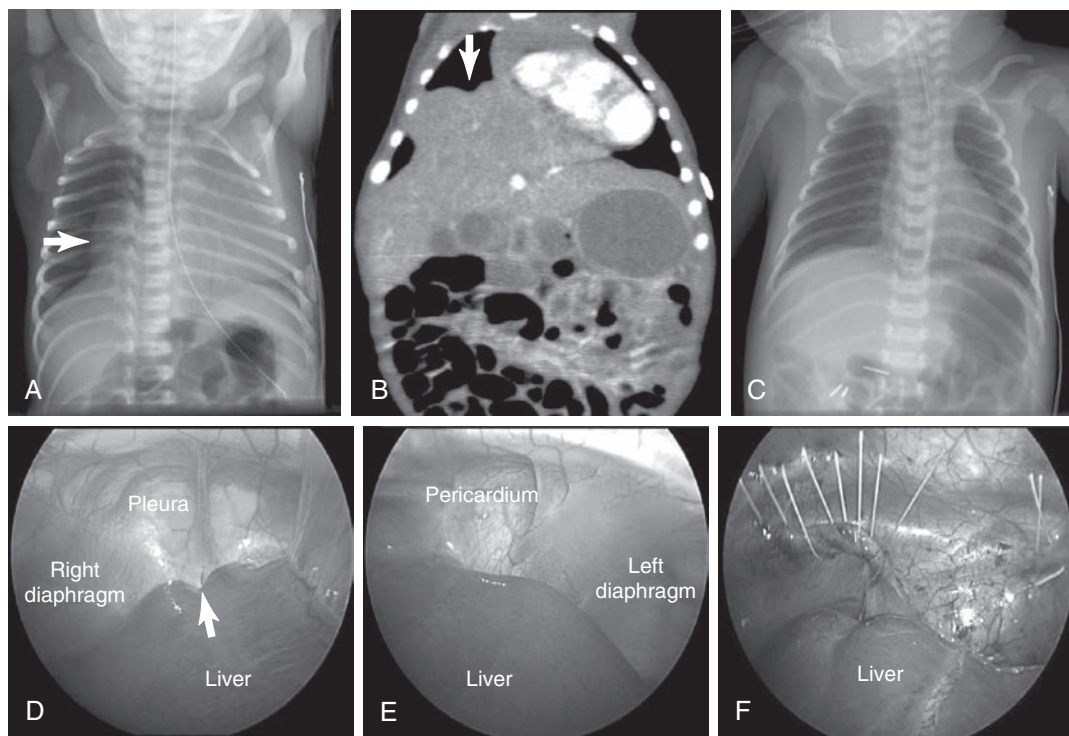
Newborn with anterior Morgagni diaphragmatic hernia. A, B, Chest radiograph and CT scan, respectively. Arrows show liver herniation. C, Postoperative chest radiograph shows complete reduction of liver and correction of hernia. D–F, Laparoscopic technique to repair large anterior defect: Right and left diaphragms are sutured to abdominal wall anteriorly; sutures are passed through the entire wall of abdomen, and knots are secured below skin level. Arrow shows groove in liver corresponding with CT scan image.
